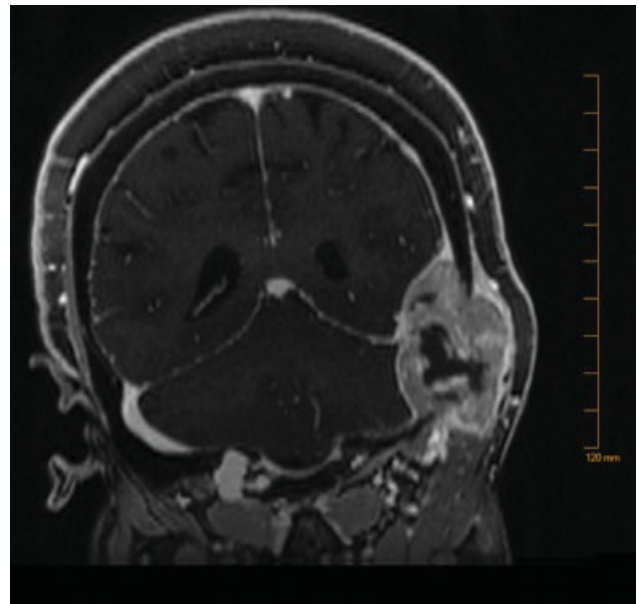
Preoperative coronal magnetic resonance imaging demonstrating a giant left-sided extra-axial mass with bony destruction. The mass measured $6 \times 5 \times 4$ cm in dimension with displacement of the adjacent brain parenchyma.
